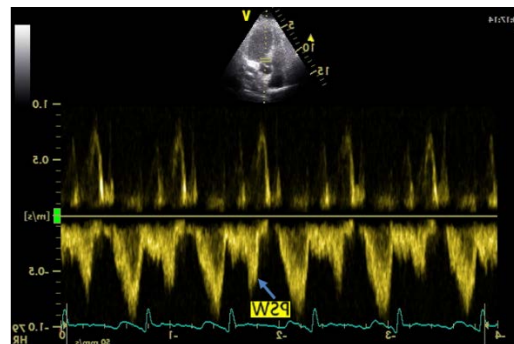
Typical appearance of a PSW on pulse-wave Doppler examination of the LVOT.
